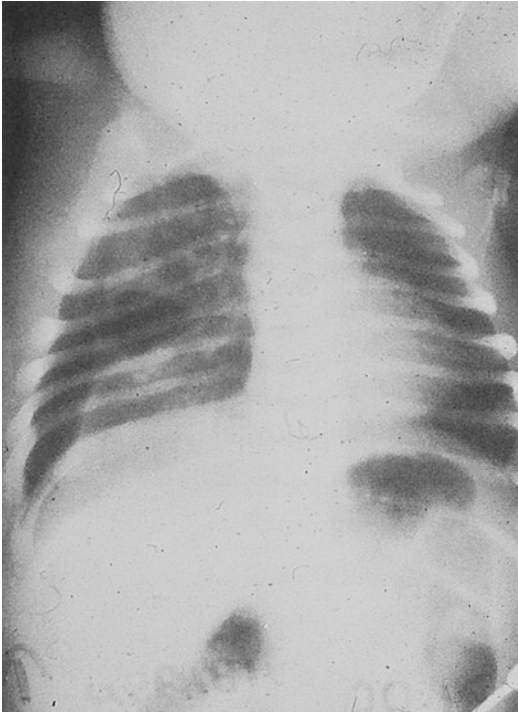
Chest x-ray showing typical right pneumothorax because of leaking EA anastomosis
